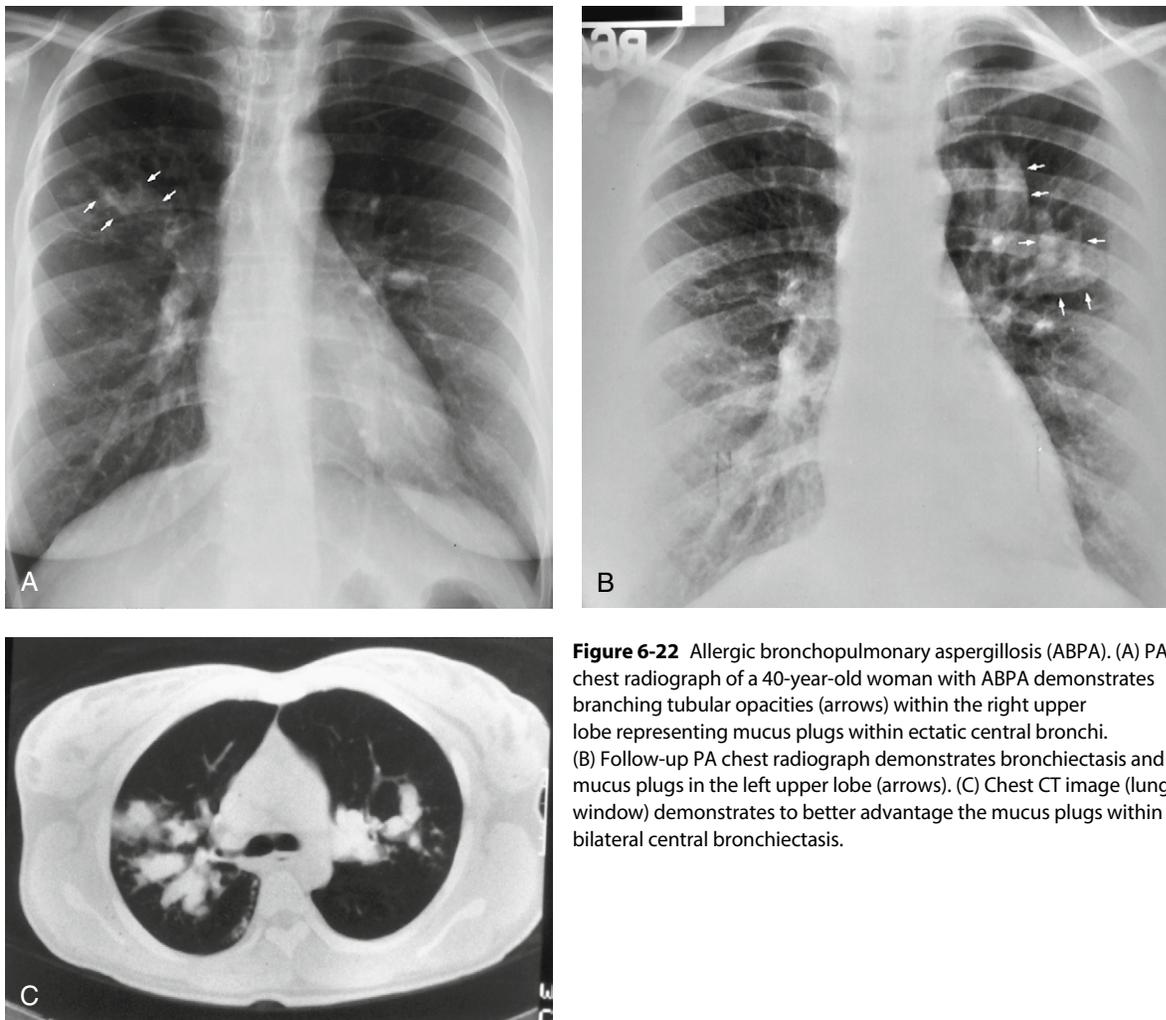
Allergic bronchopulmonary aspergillosis (ABPA). (A) PA chest radiograph of a 40-year-old woman with ABPA demonstrates branching tubular opacities (arrows) within the right upper lobe representing mucus plugs within ectatic central bronchi. (B) Follow-up PA chest radiograph demonstrates bronchiectasis and mucus plugs in the left upper lobe (arrows). (C) Chest CT image (lung window) demonstrates to better advantage the mucus plugs within bilateral central bronchiectasis.
